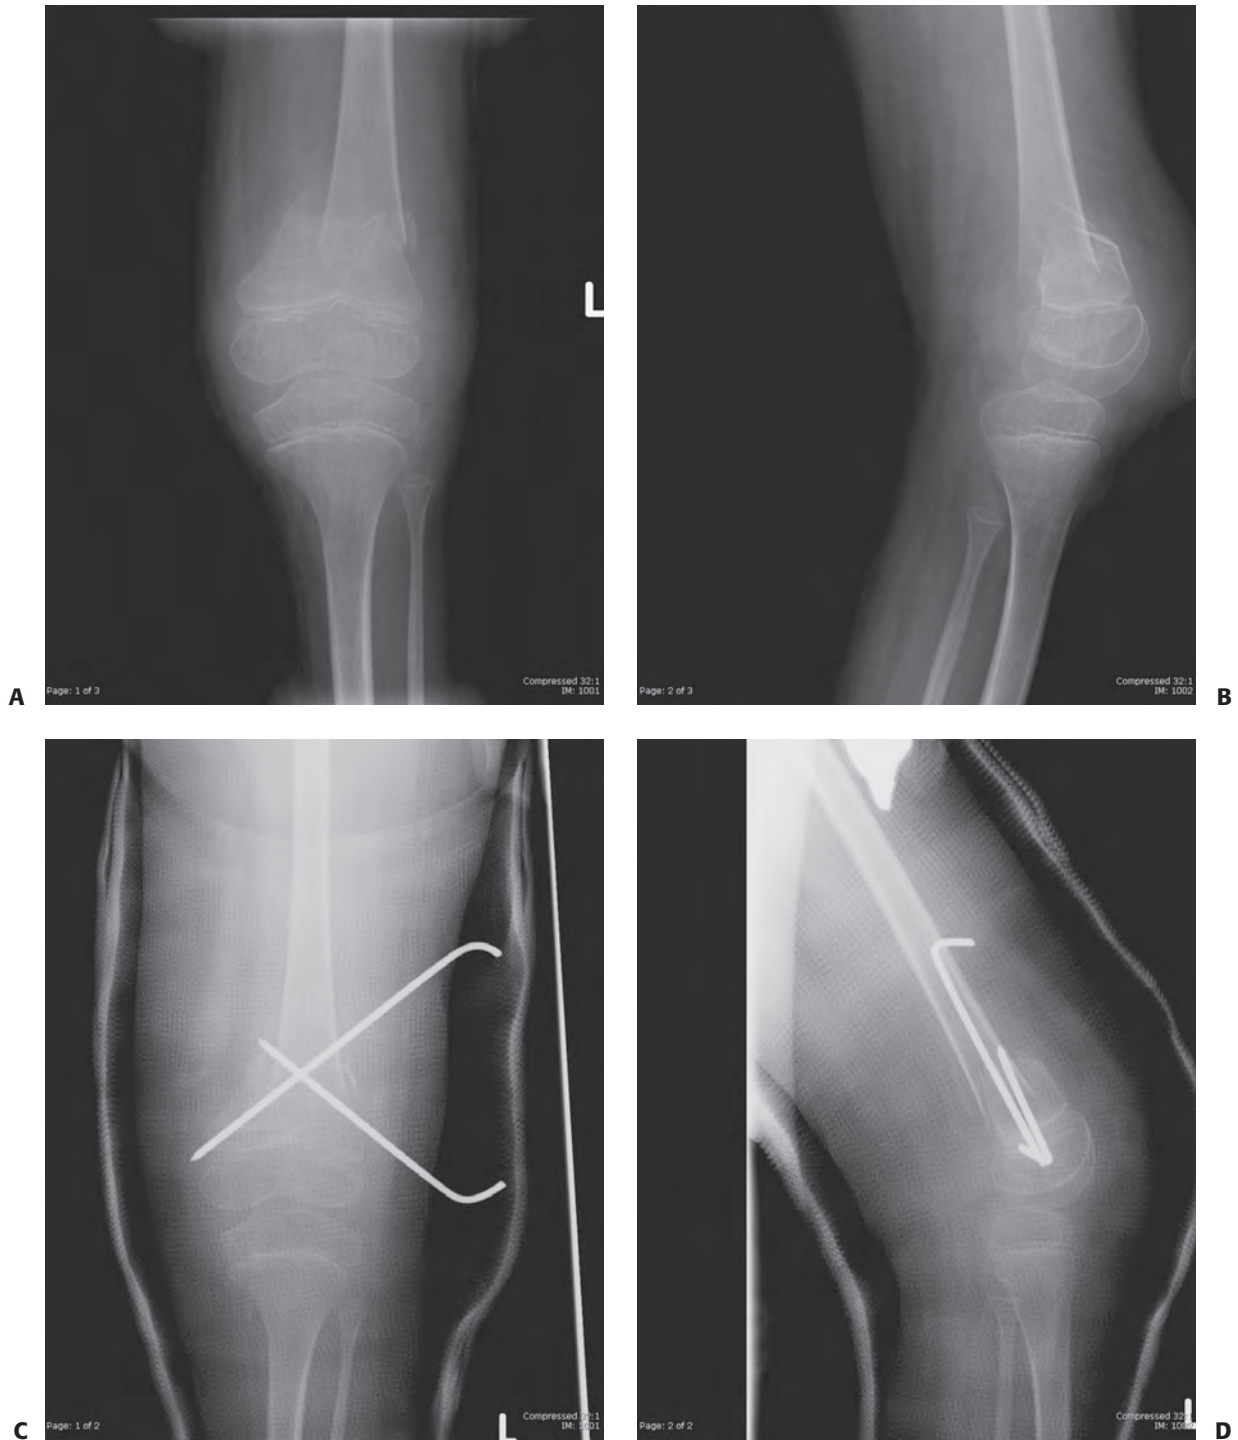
An 11-year-old boy with total body involvement cerebral palsy was receiving physical therapy when he developed pain and swelling around the left knee. Radiographs showed displaced femoral supracondylar fracture (A, B). To be able to fit to the brace adequately, closed reduction and percutaneous pinning was performed (C, D).
